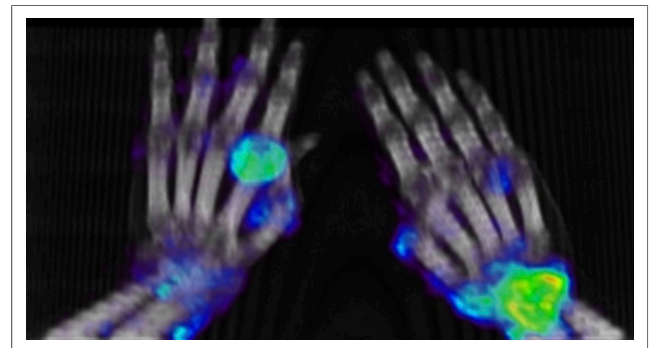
^{89}Zr -rituximab PET/CT scan of patient with active rheumatoid arthritis, demonstrating increased radiotracer uptake involving left second metacarpophalangeal joint and right wrist. (Image courtesy of Dr. Conny van der Laken, Afdeling Reumatologie, VU Universitair Medisch Centrum, Amsterdam.)
